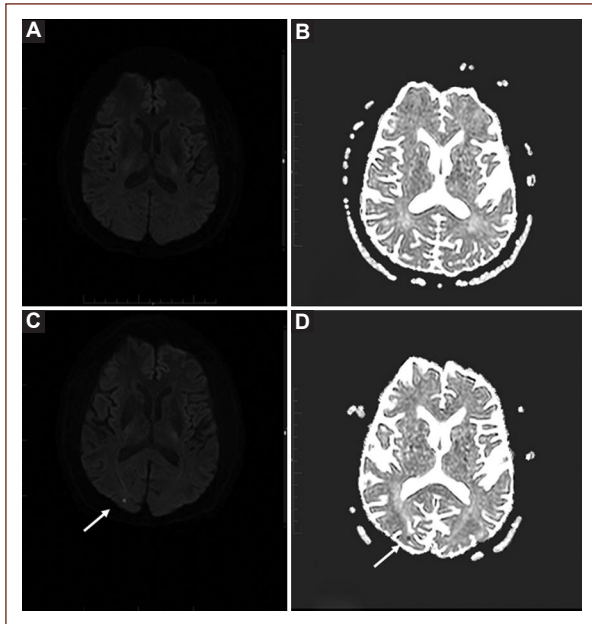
A: magnetic resonance imaging of the brain with diffusion-weighted imaging, and the apparent diffusion coefficient map (B). It was conducted 24 h before the placement of the right carotid stent, showing no significant findings. C and D: a white arrow indicates an area with focal restricted fluid diffusion located in the right occipital hemisphere, performed 24 h after the insertion of the left carotid stent.
